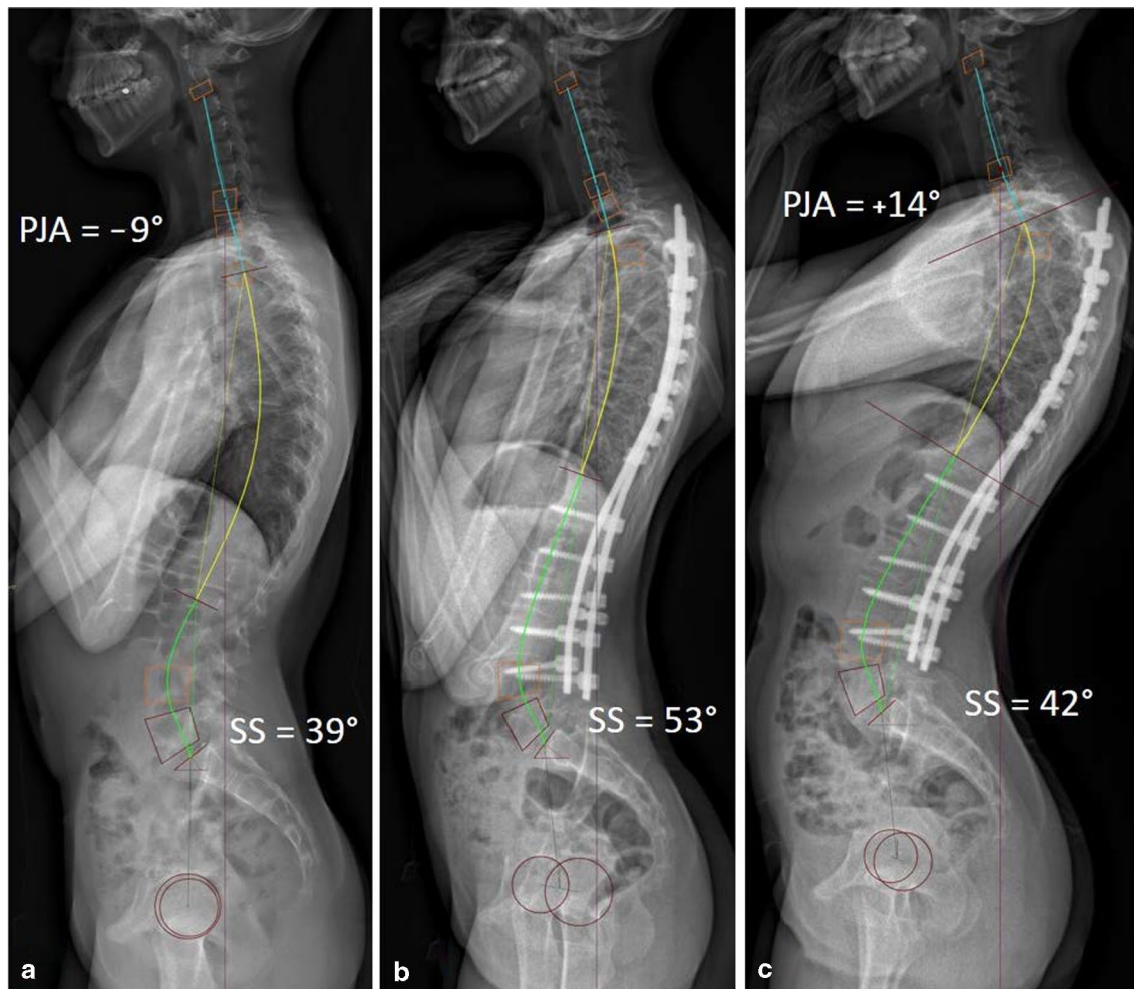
PJK in a long construct. a: Pre-operative X-ray. $PT=1^\circ$; $PI=40^\circ$; $LL=65^\circ$; $PSTK=52^\circ$. b: Post-operative X-ray. The pelvic anteversion compensates for insufficient TK and ensures spine
